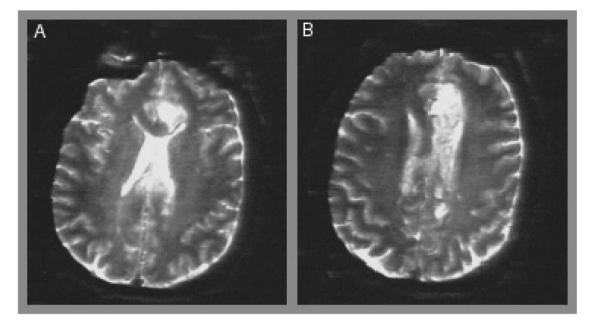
Axial T2 MRI scan demonstrating the left mesial frontal lesion (A) and the extension to the corpus callosum (B).
